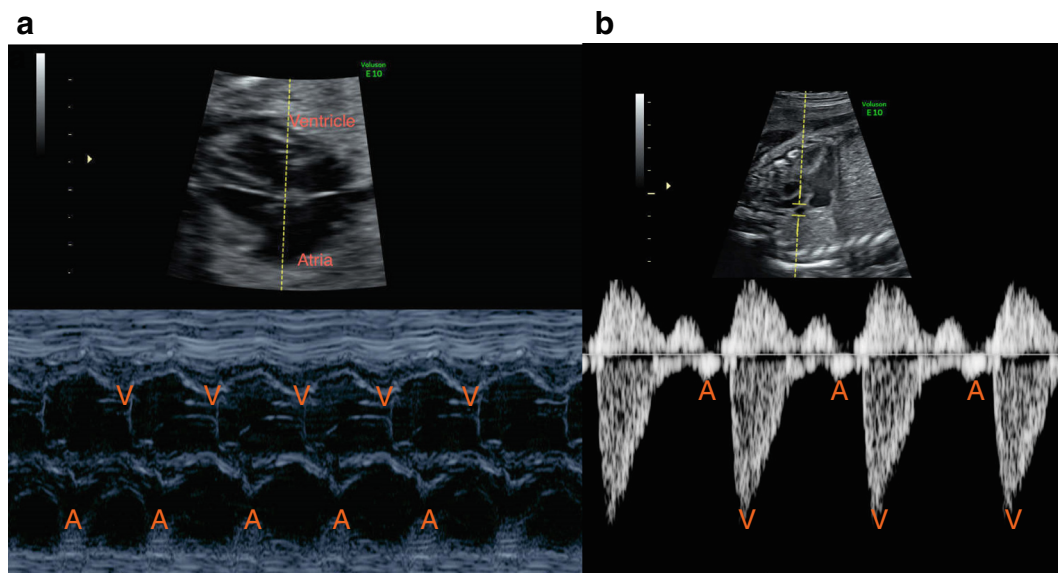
a M-mode with normal 1:1 AV conduction showing movement of the atrial and ventricular walls. b SVC/Aorta Doppler pattern. A-wave of the SVC represents atrial contraction and aortic outflow correlates with ventricular contraction and can be used to determine AV conduction time.
